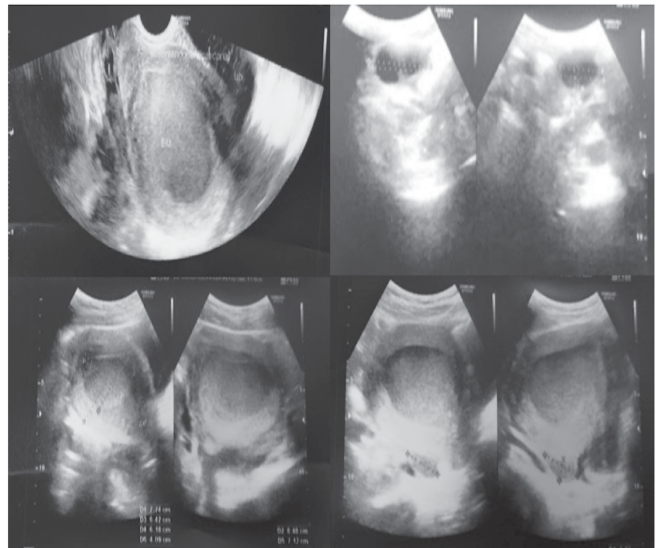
Sonographic features suggestive of cervicovaginal agenesis, thin endometrium with hematometra, bilateral endometriotic cysts and left hematosalpinx.
